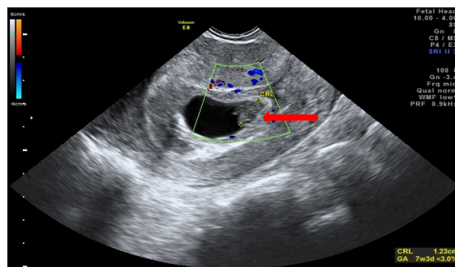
The repeat ultrasonography revealed single intrauterine gestation with CRL = 1.23 cm corresponding to 7 weeks 3 days (red arrow).
